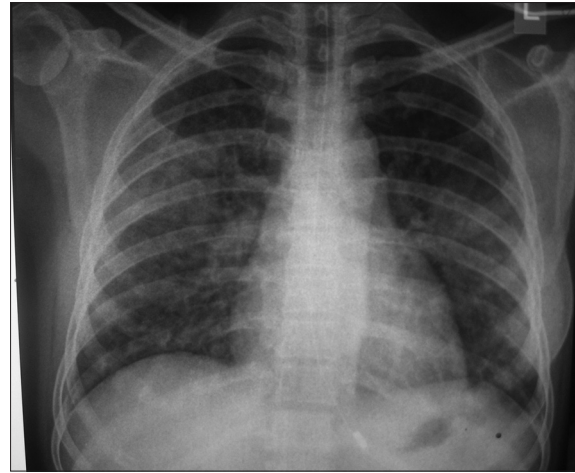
Chest radiography showed bilateral diffuse fluffy infiltrates (case 2)
